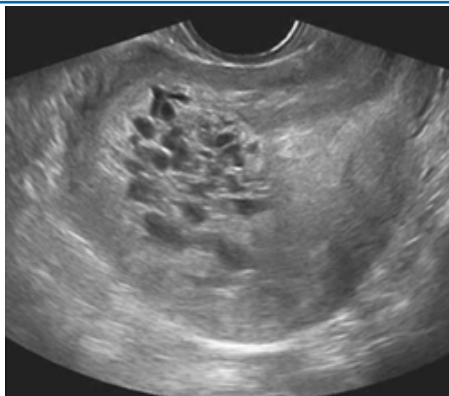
Figure B- Transvaginal ultrasound showing a classic appearance of a complete molar pregnancy ("snowstorm" or "cluster of grapes" appearance)
